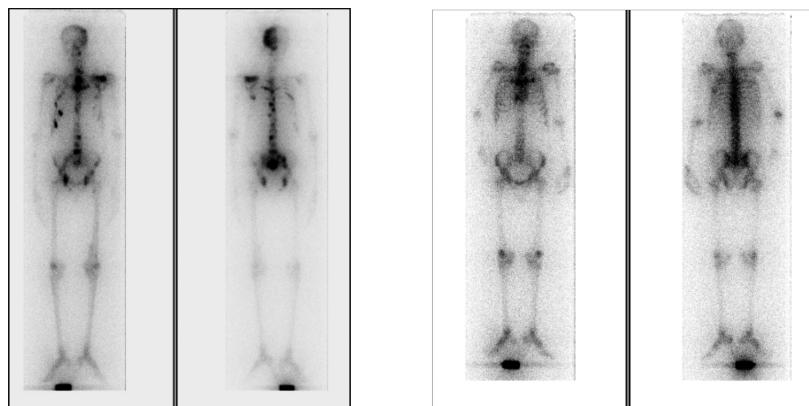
SPECT images with ^{177}Lu -EDTMP in a patient with prostate cancer with metastasis (left two images, anterior and posterior) and in a patient without metastasis (right two images, anterior and posterior) (courtesy C. S. Bal, AIIMS, India, unpublished results).
